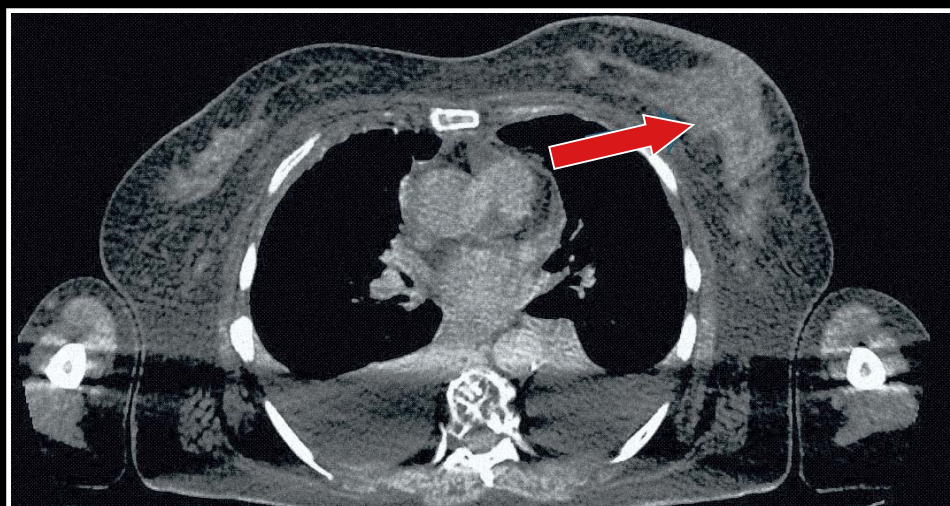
Low dose CT Scan that shows multiple osteolysis processes due to osteoporosis, multiple pre- and infra-carinal adenopathies and a suspicious aspect of the left breast (arrow), skin thickening and possible nodules. Results were confirmed by mammogram
